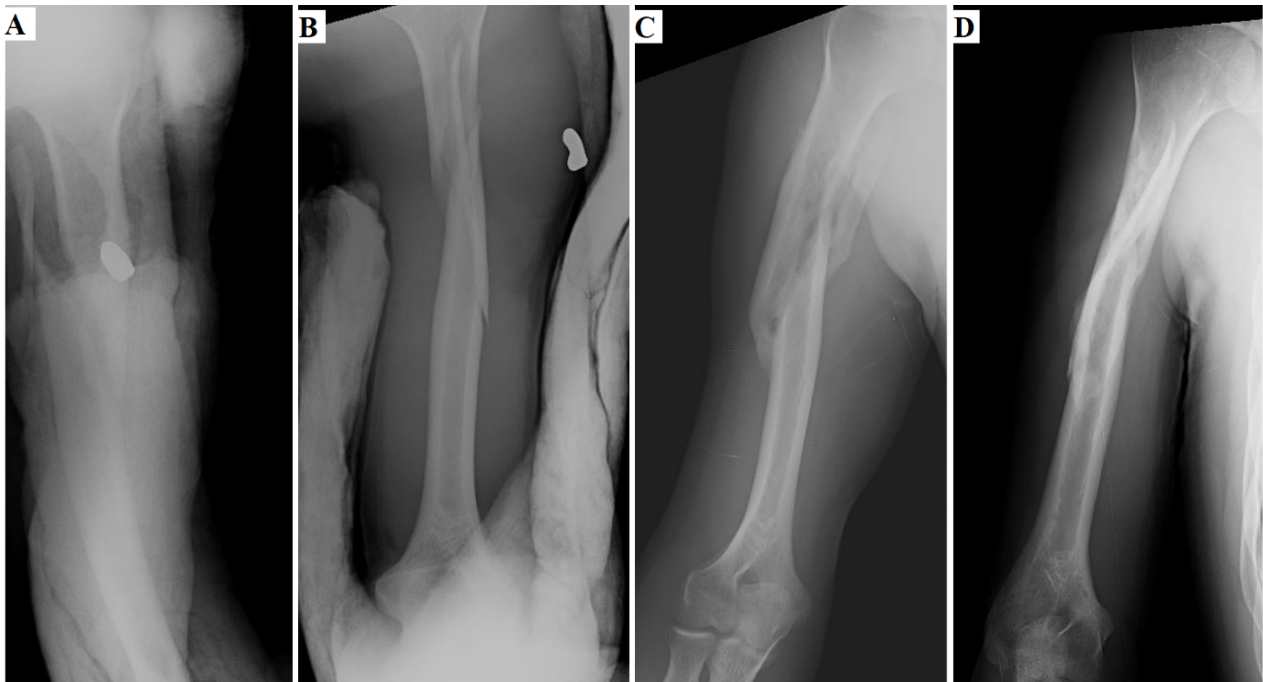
Fracture of the diaphysis of the humerus treated with conservative treatment (A,B: radiography images with splints, C,D: radiography images after union)
